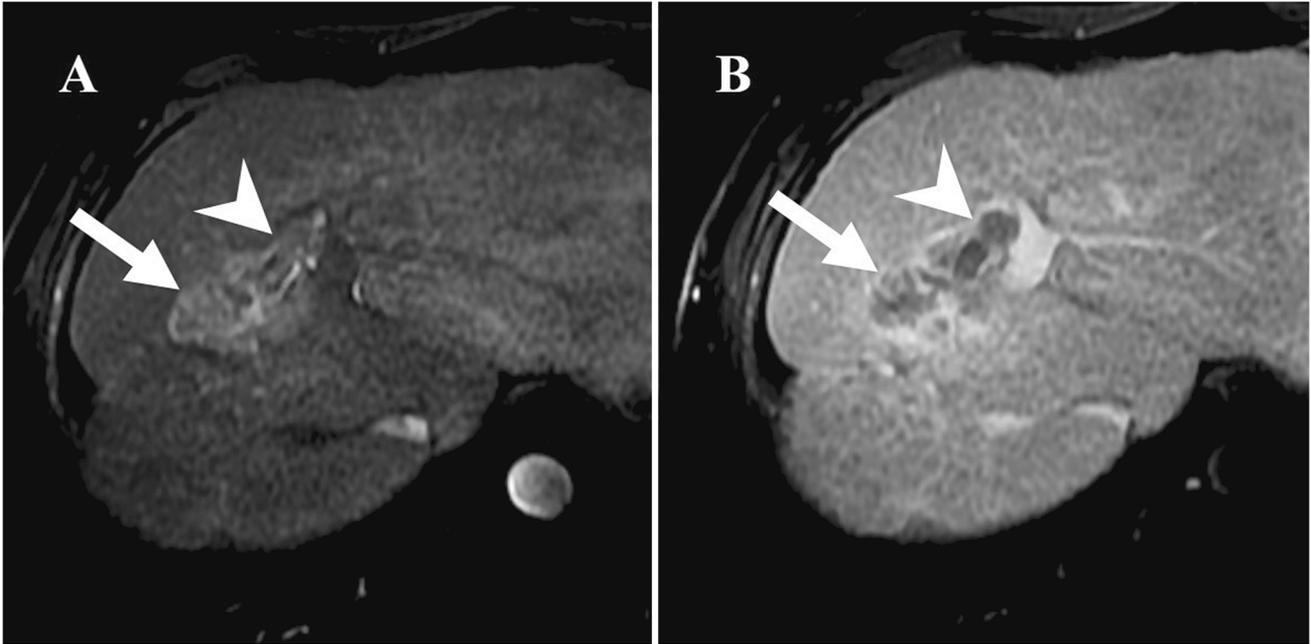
70-year-old male with HBV cirrhosis. Gadoxetate-MRI demonstrates a 3.8 cm heterogeneous rim-APHE observation on HAP (a) and persistent peripheral enhancement on PVP (b), thus classified as LR-M. Gross
